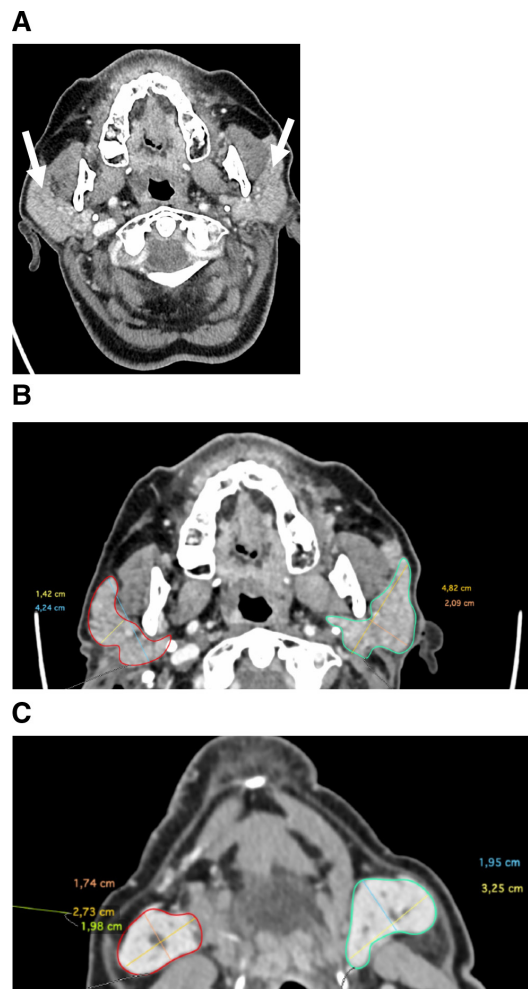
CT of the head showing bilaterally enlarged parotid glands (A) overview (arrows), (B) parotid glands, (C) submandibular glands. Red left, green right. The CT scan shows slightly enlarged parotid and submandibular glands (arrows) on both sides, with some differences in volume between sites.
